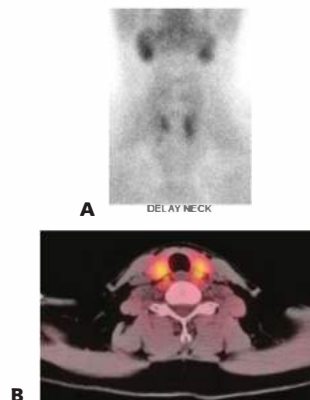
• Nuclear medicine parathyroid scan. A. 2-hour delayed planar view showing bilateral parathyroid adenomata. B. Fused sestamibi-SPECT/CT scan showing bilateral sestamibi-avid parathyroid lesions posterior to each lobe of the thyroid gland.
